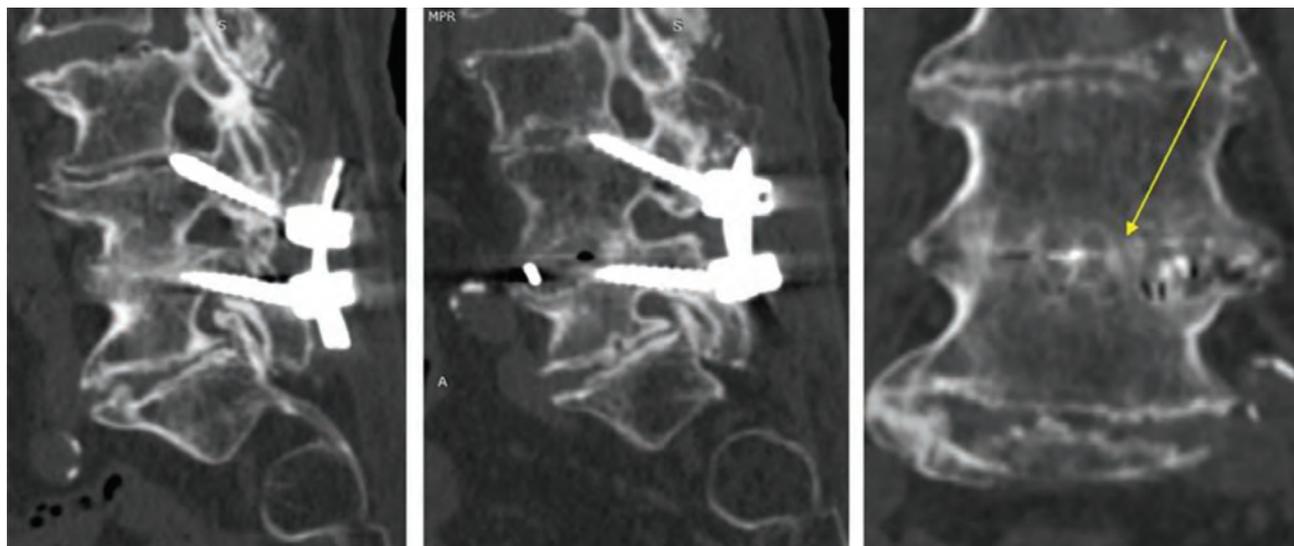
Three-year CT scan demonstrating delayed successful L4-L5 fusion, with continuous bony fusion mass inside and outside the cages (arrow), and resolution of radiolucency around the implants.
